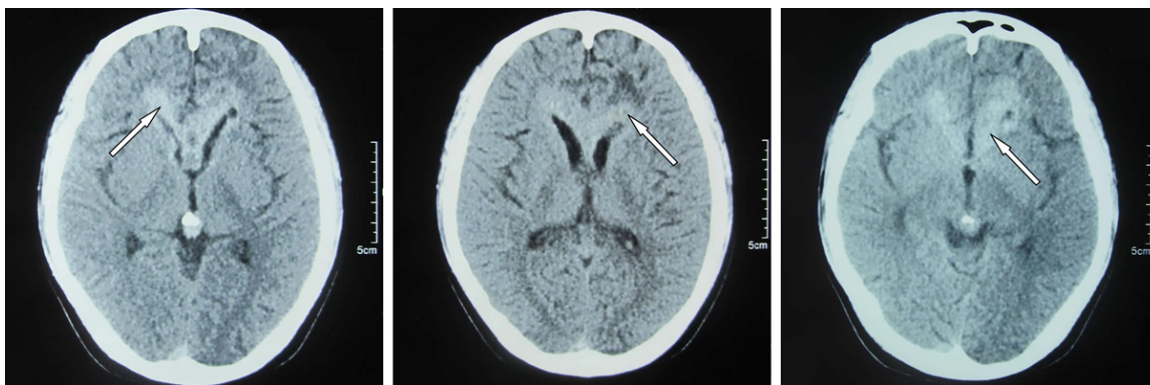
CT scans findings. Axial images showing high density with multiple irregular lesions.
